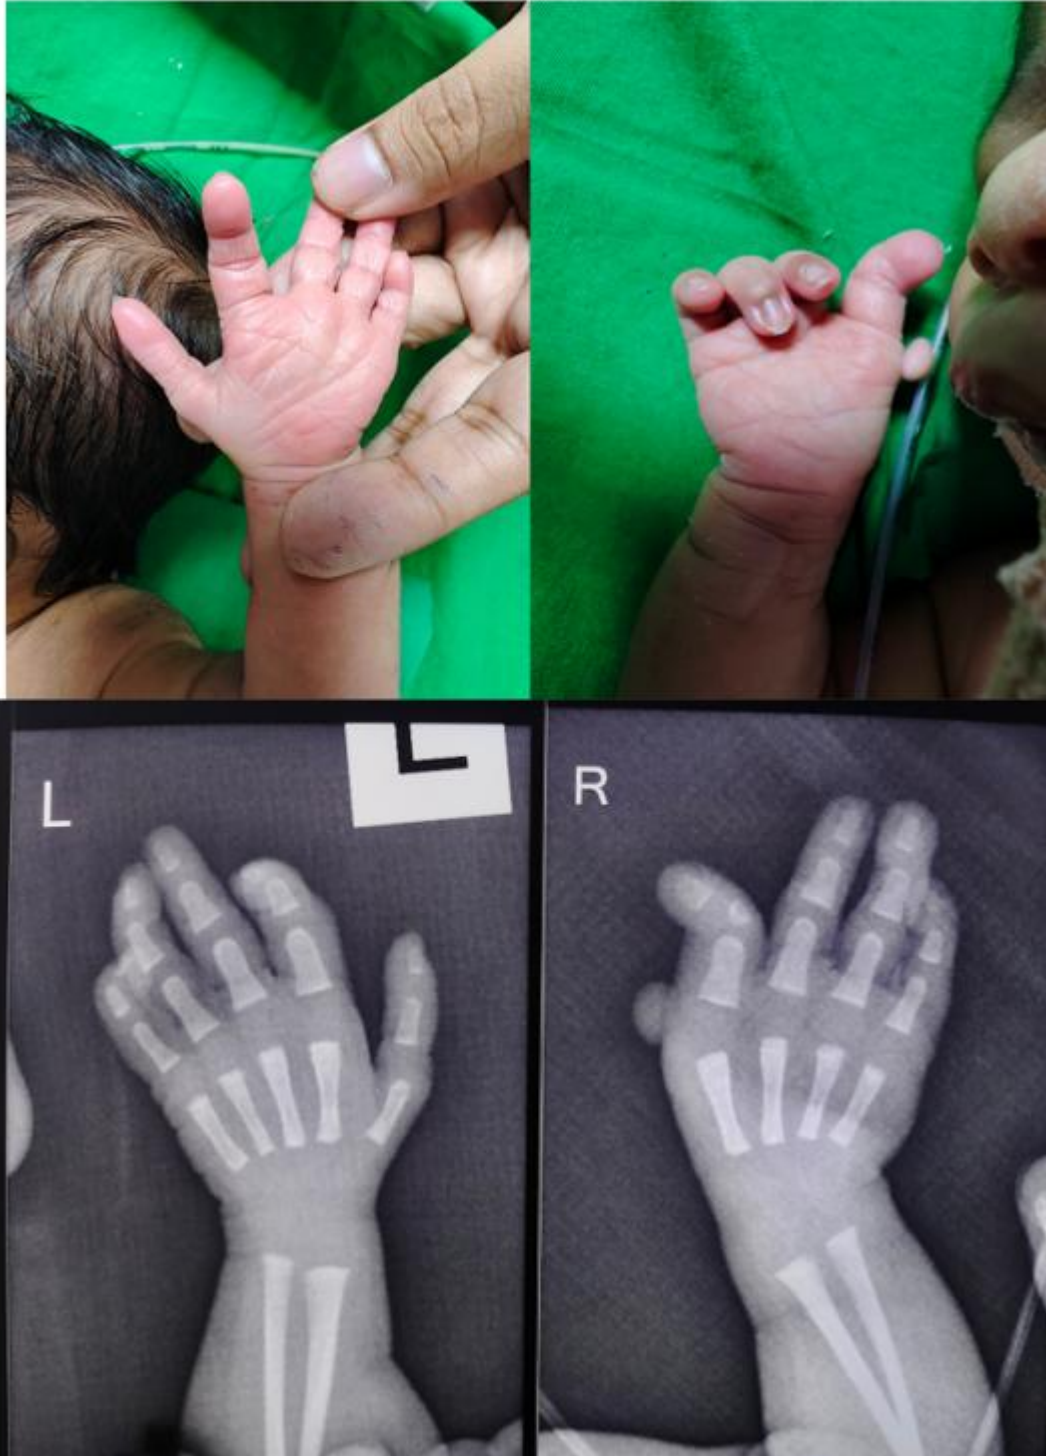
Gross appearance and x-rays of hands showing Thumb Hypoplasia (Left) and Thumb Aplasia (Right)
